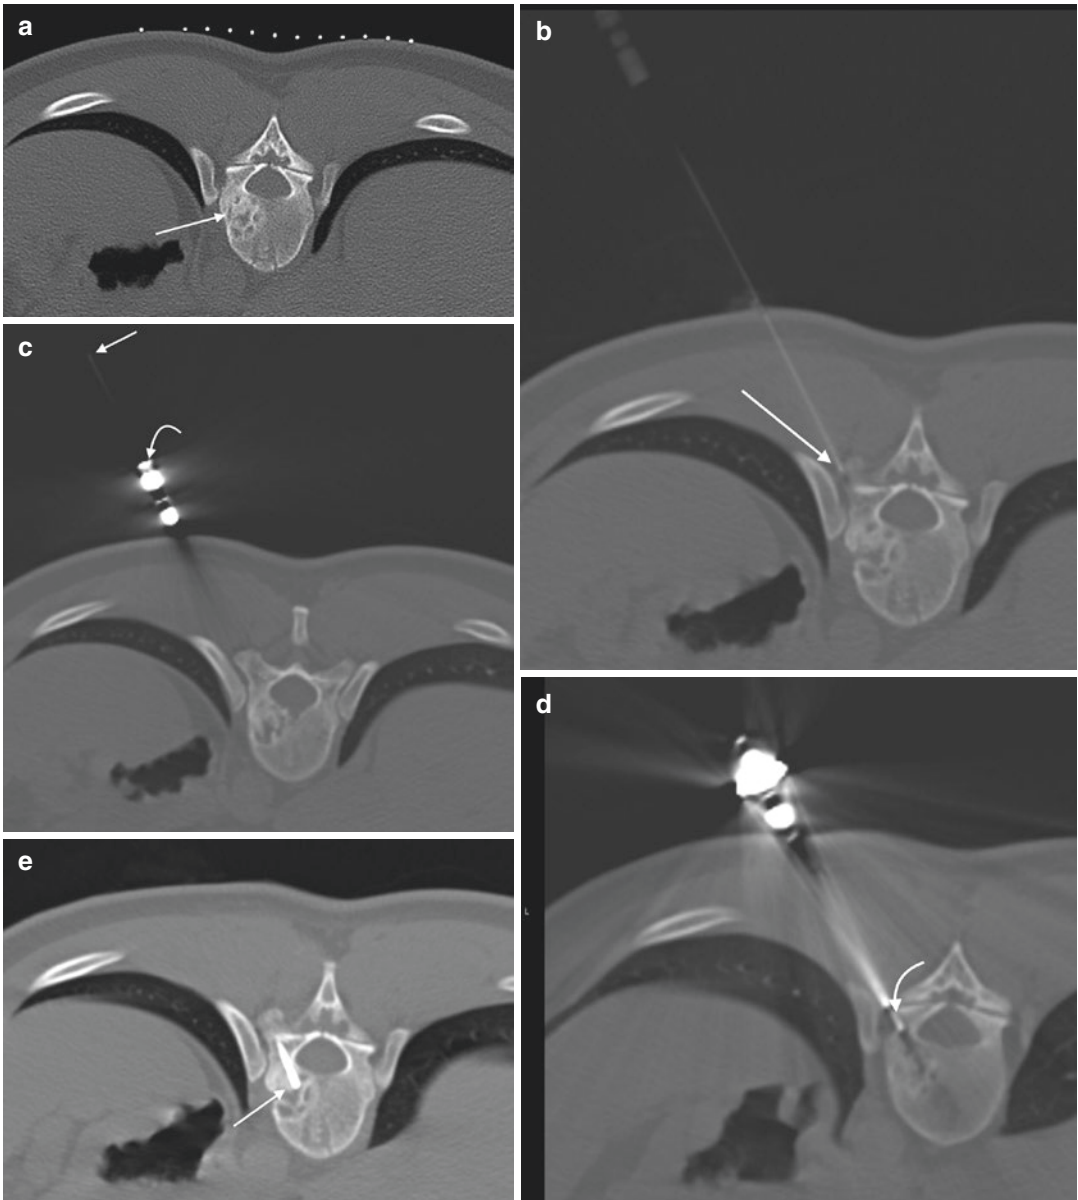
A 29-year-old male with incidental lesion detected on outside study. Axial CT image (a) from the biopsy procedure with a skin grid in place shows a mixed sclerotic lesion within the posterior vertebral body (arrow). Axial CT image (b) shows tip of 20 gauge insert needle (arrow) adjacent to the transverse process. This needle was used to administer 2% lidocaine; the hub of the needle is removable so that it becomes a guidewire.
